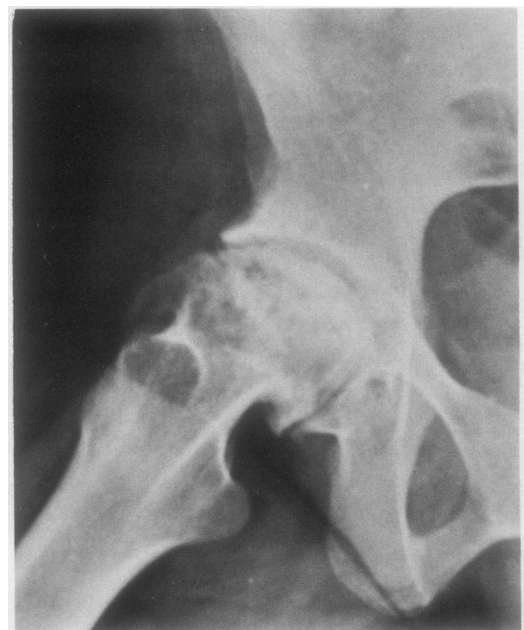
Plain radiograph of a femoral head with stage IV subchondral avascular necrosis showing the destructive arthritis with osteophytes and sclerosis affecting both sides of the joint mimicking osteoarthritis.
